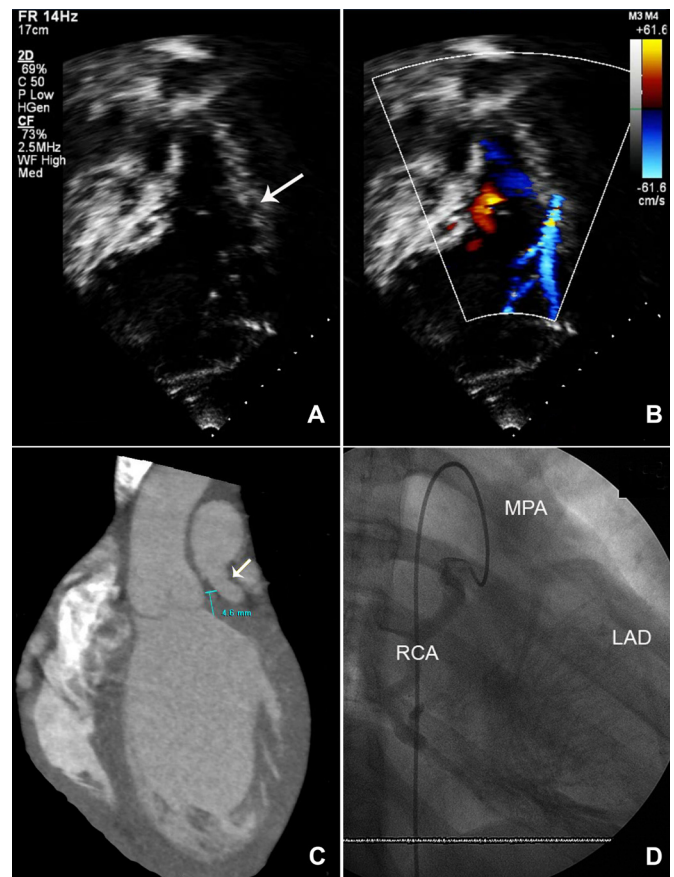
A, Transthoracic echocardiography showing the left main coronary artery (LMCA) originating from the pulmonary artery (PA) (arrow). B, Color Doppler reveals the retrograde flow from the LMCA to the PA. C, Multislice computed tomography coronary angiography showing the left main coronary artery arising from the main pulmonary artery (arrow). D, Coronary angiography demonstrating a dilated right coronary artery (RCA) giving rise to multiple dominant septal collaterals to the left anterior descending artery (LAD), which arose from the main pulmonary artery (MPA).
